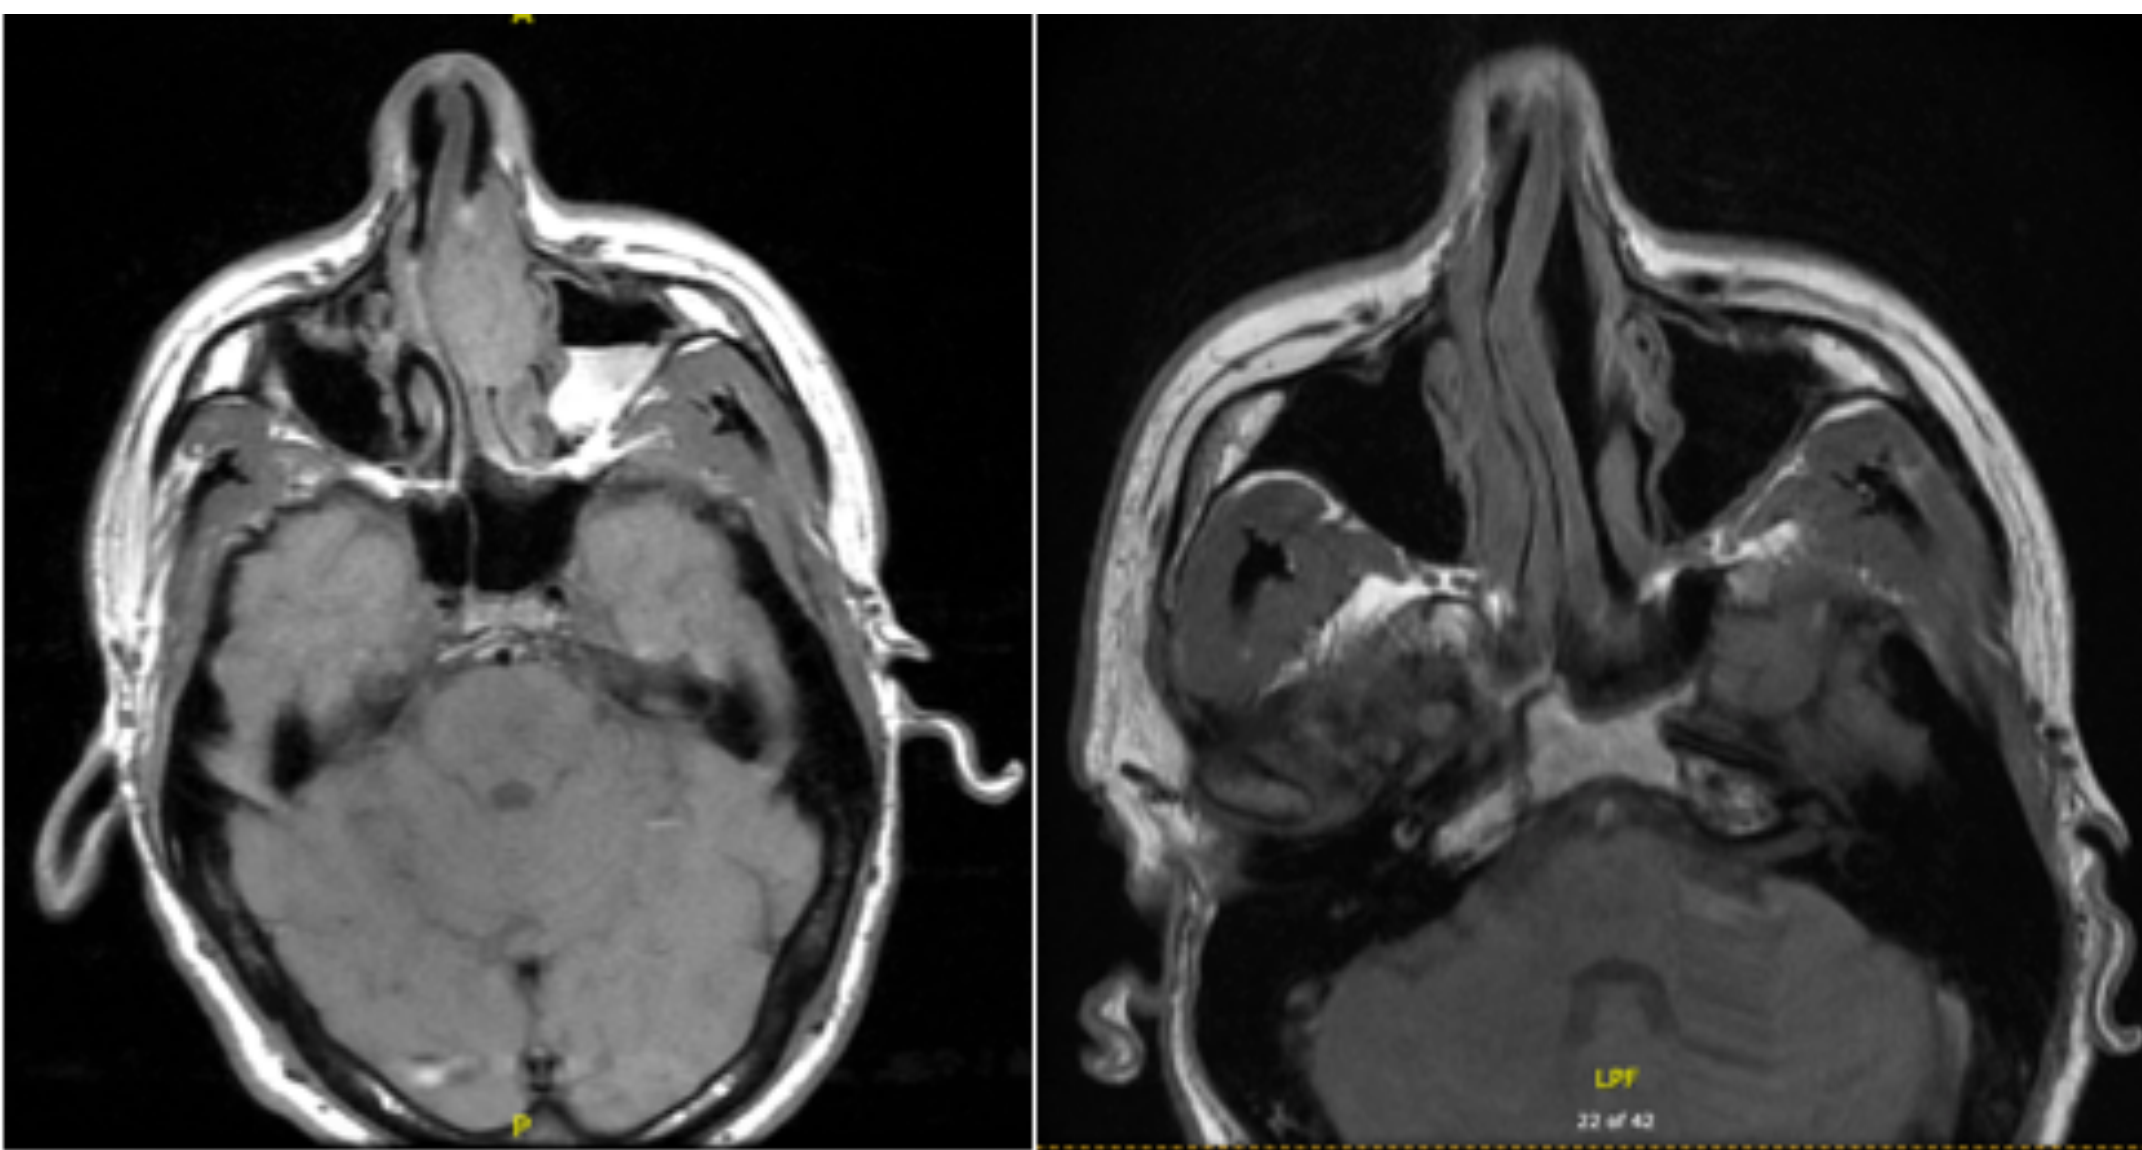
(left) MRI neck T1 pre-contrast with left nasal cavity mass and air-fluid level of left maxillary sinus. (right) T1 pre-contrast MRI face at 5 months’ post-treatment with no evidence of residual or recurrent disease.
